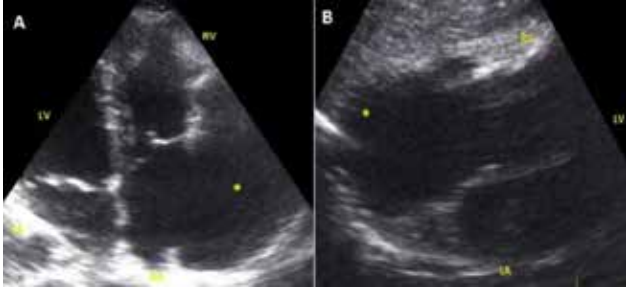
(A, B) Two-dimensional transthoracic echocardiography. A. Four chamber view. Asterisk points possible right atrial aneurysm. Left atrium (LA), left ventricle (LV), right atrium (RA), right ventricle (RV) are also seen. B. Subcostal view.
